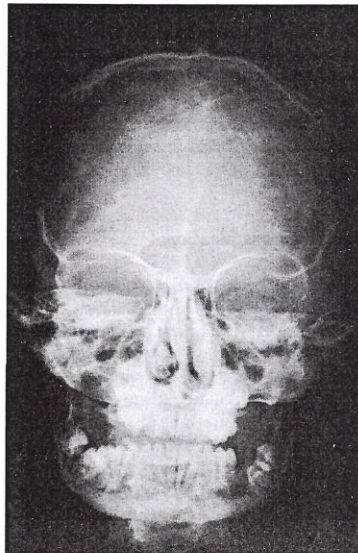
P.A. radiography of patient's skull at age 13 10/12. Extended radiolucencies in both mandibular rami and alveolar bone loss evident in the mandibular incisor and molar area.
